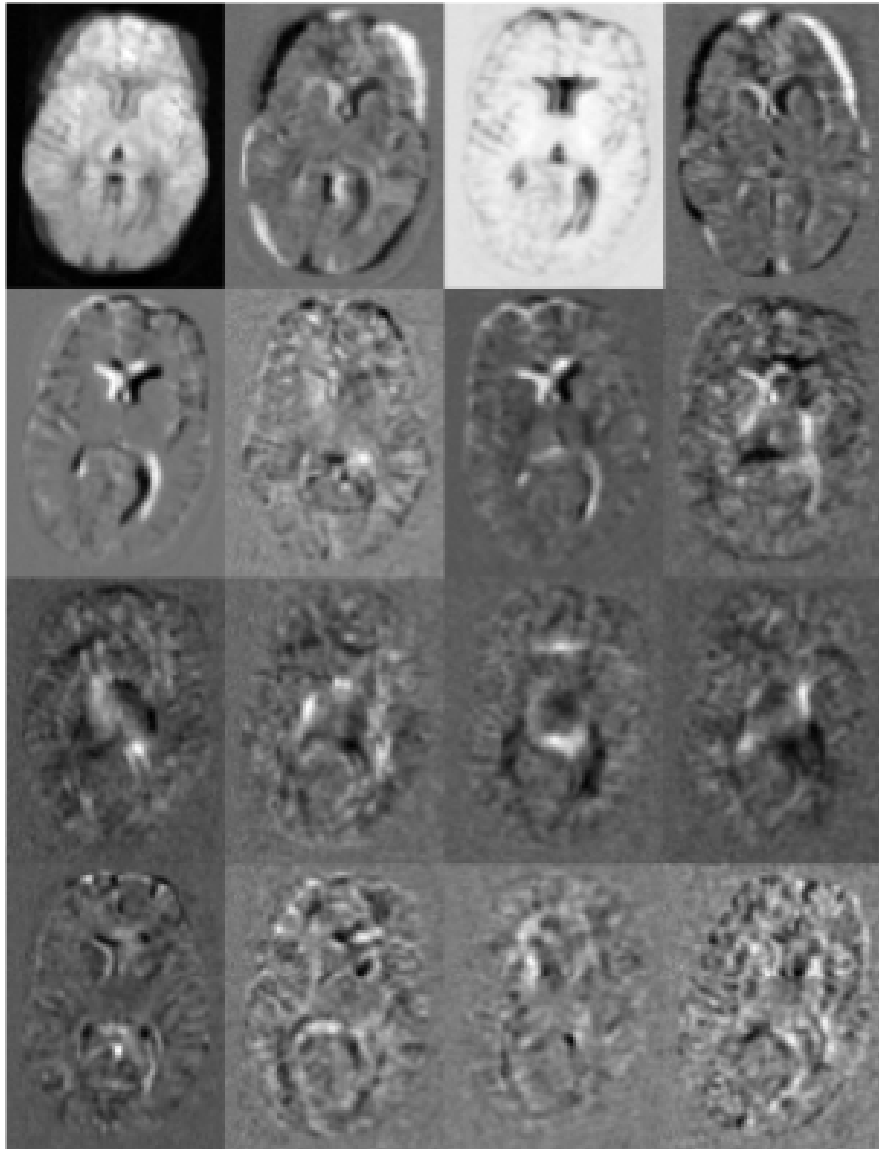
PCA decomposition of an unregistered DWI dataset (first 16 components). Images are displayed in order of decreasing variance, starting from the top left. Data variance around the edges of the images and CSF-white matter interfaces is apparent in nearly all components.
